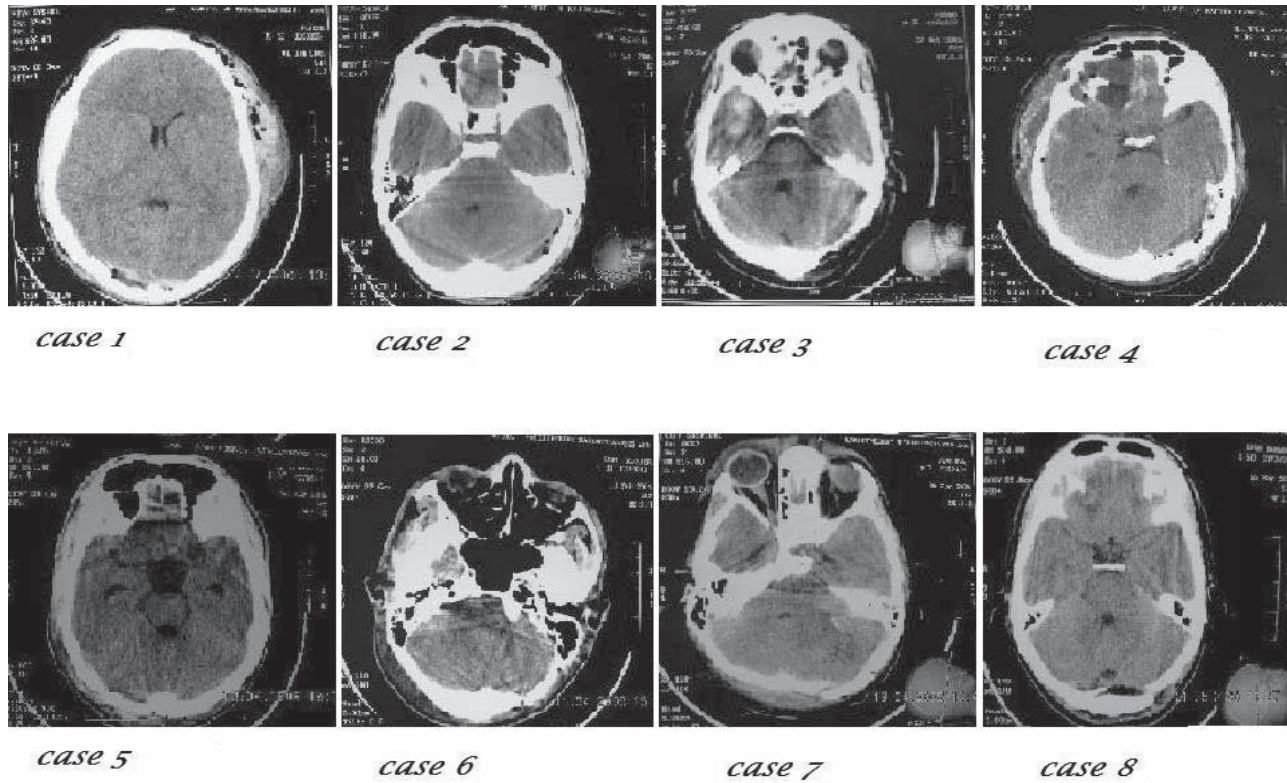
Post operative axial CT scan (representative posterior fossa cuts) of C. No. 1-8
